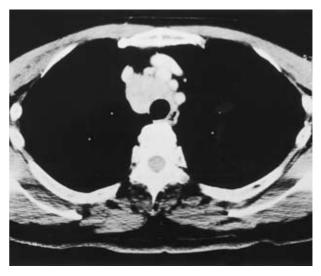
Computed tomography of the chest shows a mass compressing the right brachiocephalic vein.
